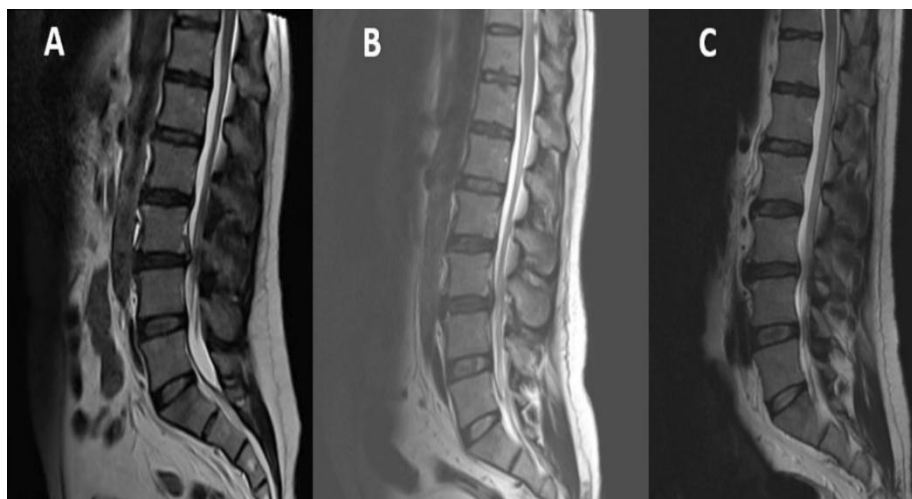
Serial postoperative lumbar MRI, showing decompression and stable conus morphology.
